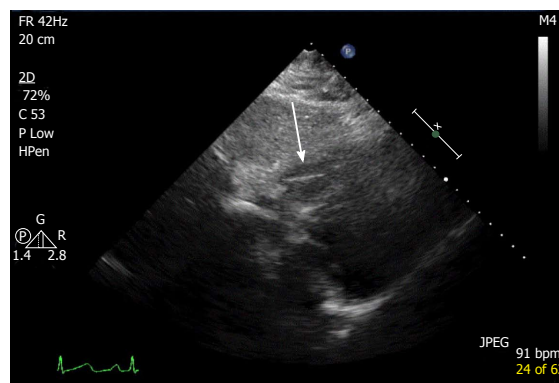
Echocardiography subcostal view showing liner foreign body in the right ventricle.
